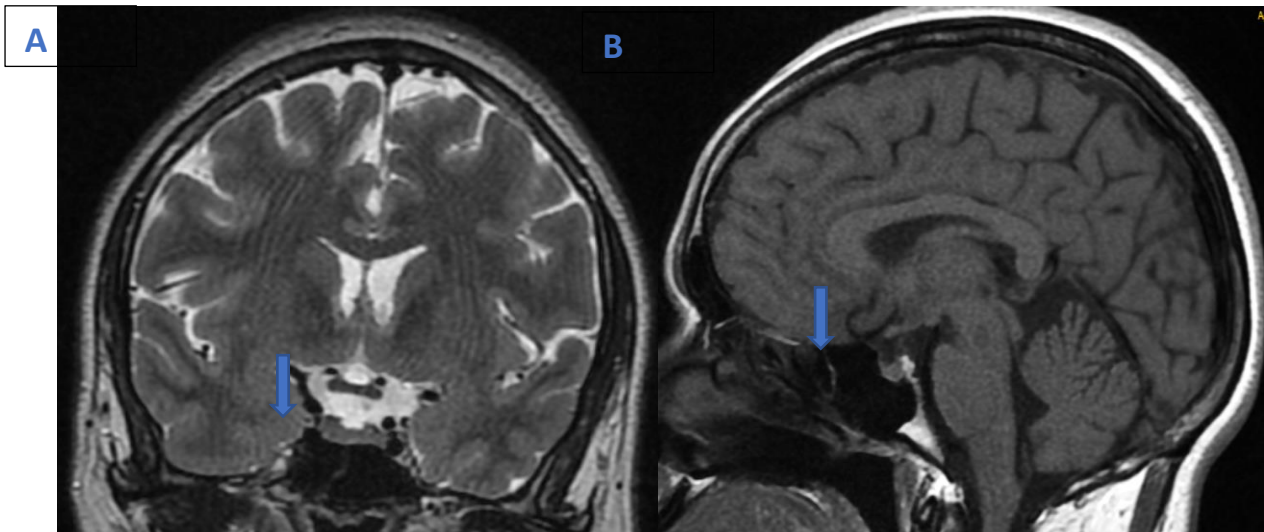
MRI of the pituitary gland showing a Rathke's cleft cyst (blue arrow), A: T2-weighted coronal section, B: T1-weighted sagittal section
